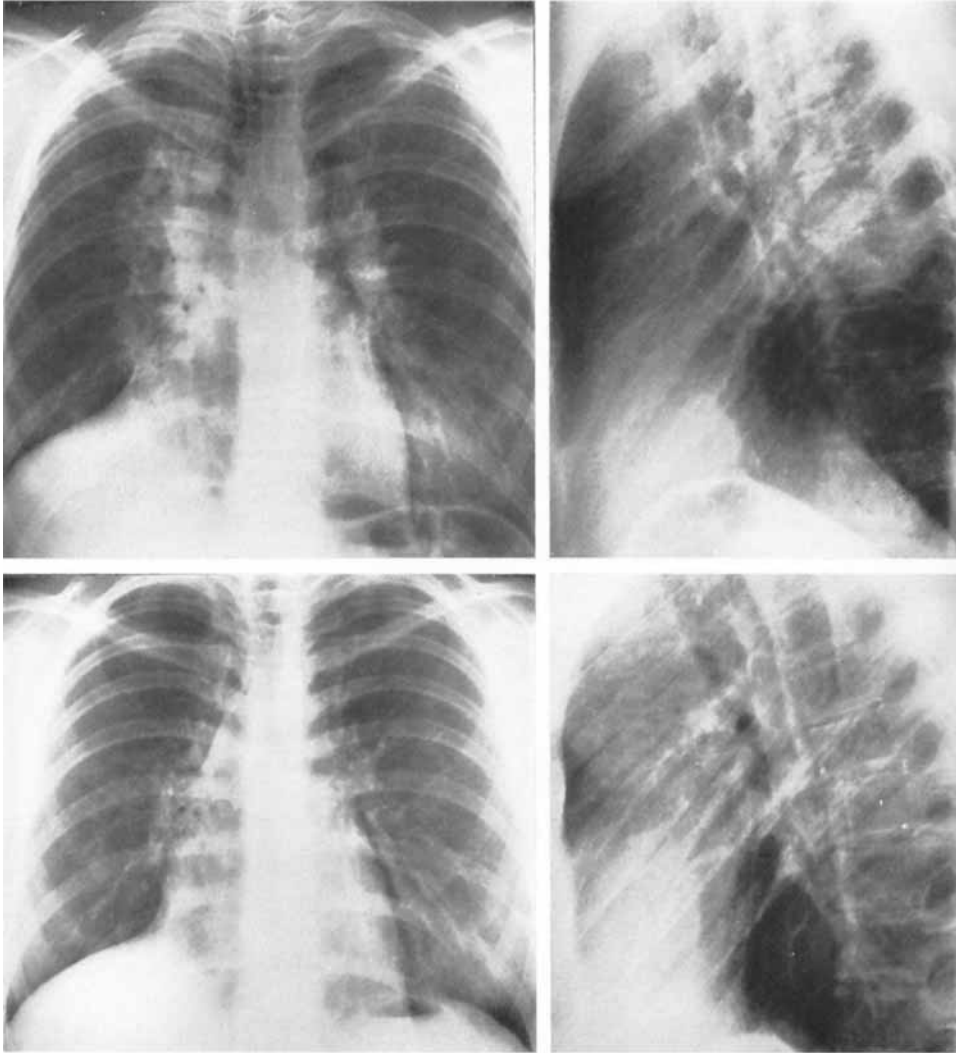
Frontal and lateral roentgenograms of patient No. 6. *Upper views:* Five months after the beginning of mantle treatment. Central pneumonitis as well as pleural changes and fibrosis on the right side; mediastinum with trachea displaced to the right. *Lower views:* Fifteen months after the beginning of mantle treatment. Further fibrosis.
